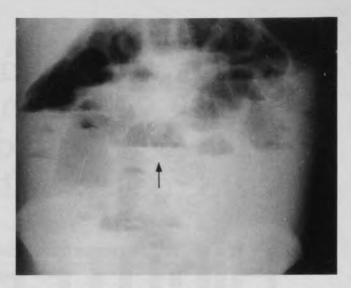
Abdominal radiograph showing dilated loops of bowel consistent with a small bowel obstruction. Arrow indicates air-fluid level.
